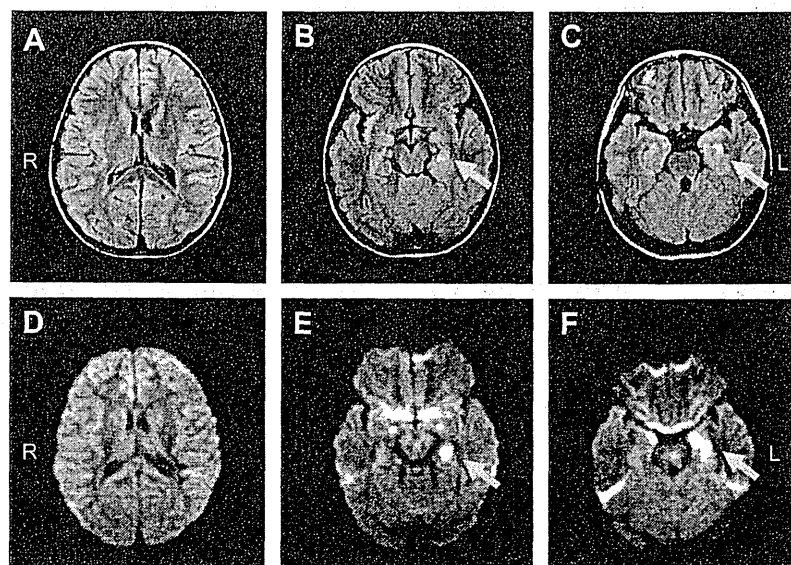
MR images of a patient with anti-NMDAR encephalitis. Axial FLAIR images (panels A–C) and diffusion-weighted (DW) images (panels D–F) of a 7-years-old girl with anti-NMDAR encephalitis. Arrows in panels B, C, E, and F show hyperintensities in the left medial temporal lobe on FLAIR and DW images.
